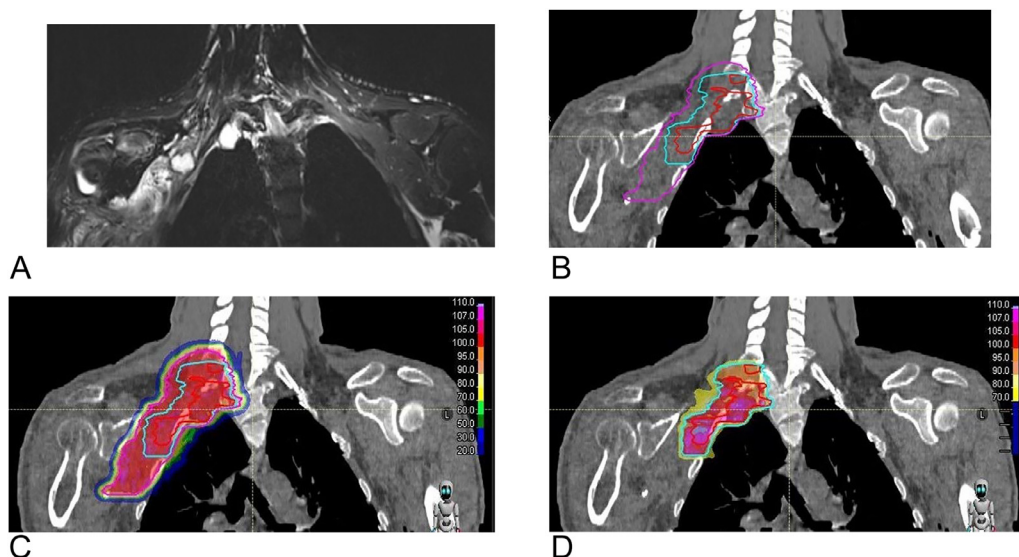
Representative plan with 2 dose levels. MPNST treated with postoperative CIRT. A 34-year-old male with high-grade MPNST, NF1-associated, and of brachial plexus with soft tissue component protruding on the right lung apex and perineural spread along the nerves. The patient underwent postoperative CIRT of 76.8 Gy (RBE) in 16 fractions for macroscopic residual disease, showing a fast increase after surgery. (A) MRI pretreatment showing residual mass. (B) Volume description: GTV is shown as the red line, CTV-HR light blue, and CTV-LR in pink. (C) CTV-LR isodose 100% red color wash. (D) CTV-HR isodose 95% orange color wash. Note that the smaller area of low-dose spillage is 20%.
